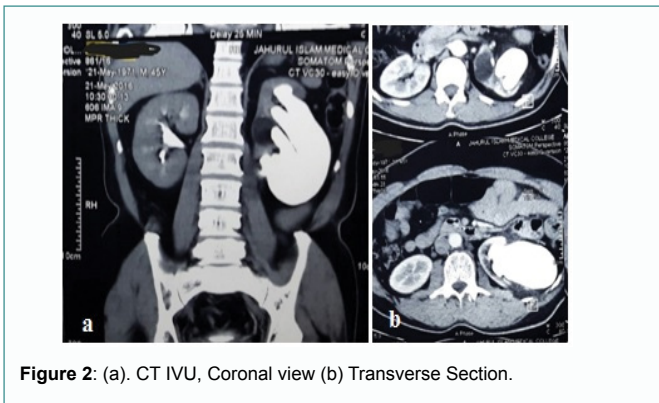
(a). CT IVU, Coronal view (b) Transverse Section.
